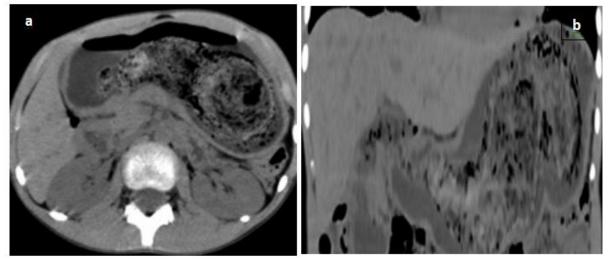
Axial (a) and coronal (b) CT scan sections showing the extension of a trichobezoar from the stomach to the second part of the duodenum
